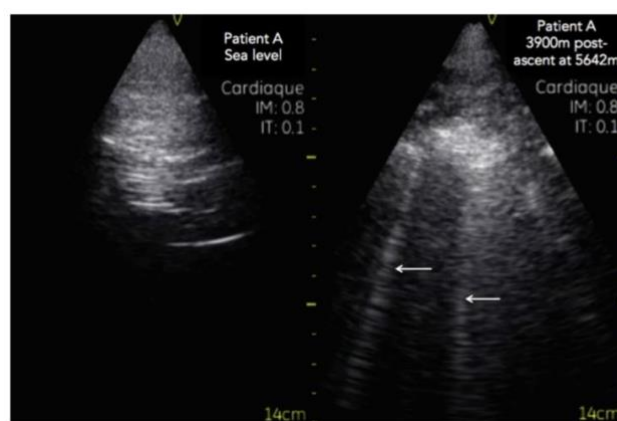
Ultrasound lung comets
